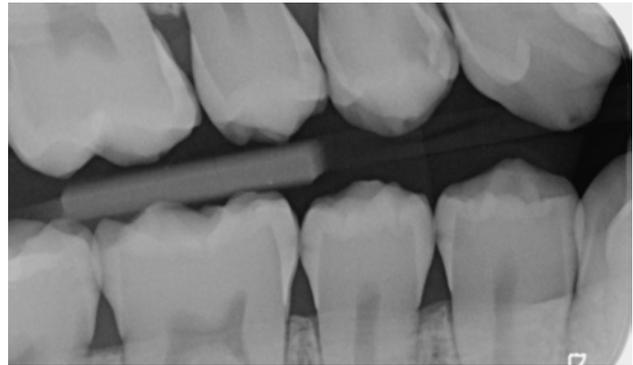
Bitewing x-ray: mesial C3 lesion in tooth 14 among other findings
